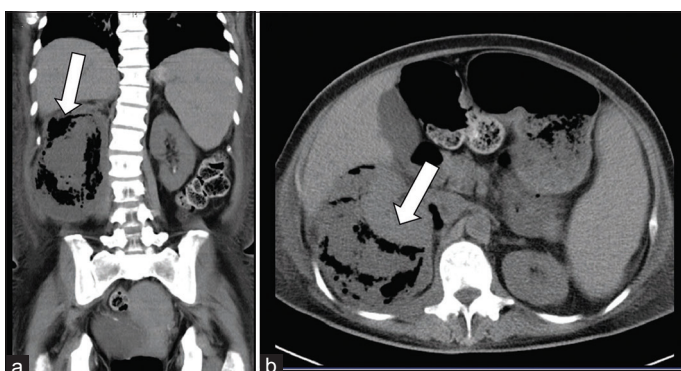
CT scan urography. (a) Coronal view; (b) Axial view. The white arrow indicated that the right kidney had a large collection of subcapsular fluid seen with air bubbles
